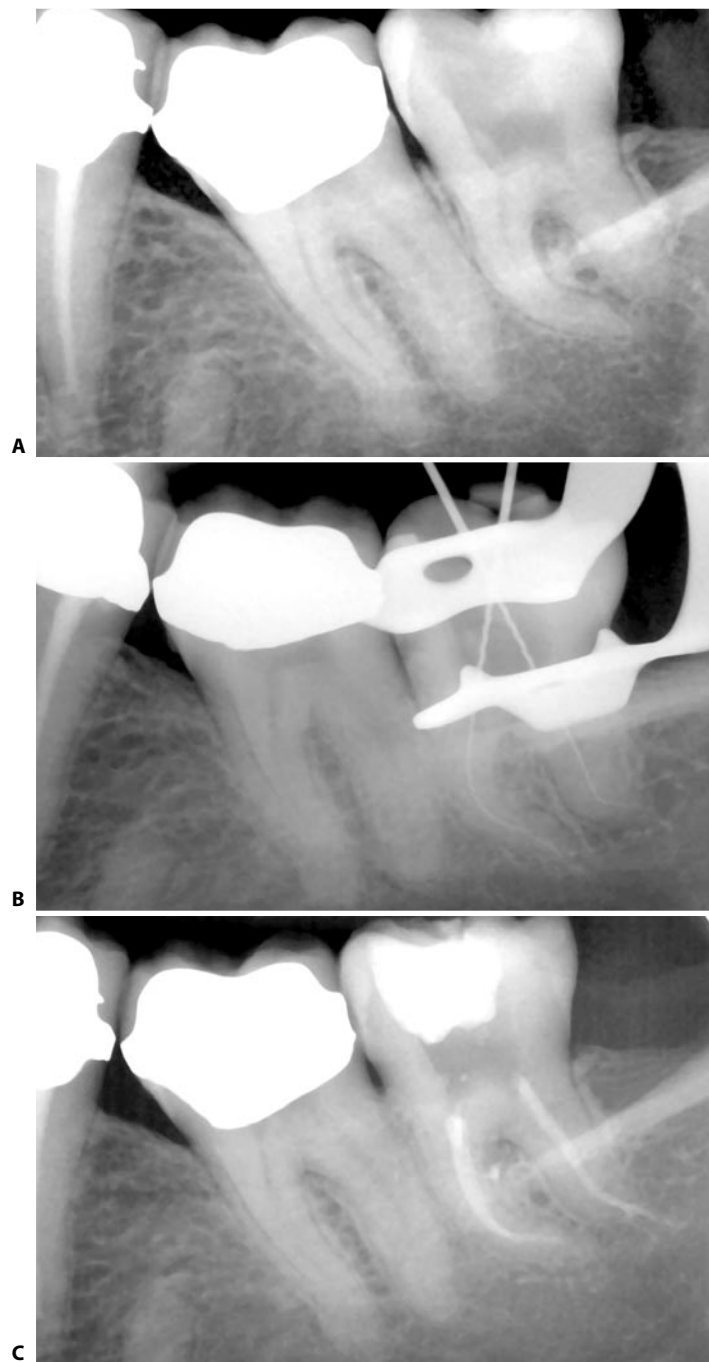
Endodontic treatment of a lower third molar. A. The preoperative radiograph shows the presence of rather short roots and accentuated curvature as well as very narrow canals. B. Intraoperative radiograph. C. Postoperative radiograph: note the obturation of a lateral canal situated at the level of the coronal third of the mesial root. The fine thickness of the distal walls of the mesial canals have been respected. The obturation using the Microseal Technique was carried out using a # 25 tip diameter condenser with .02 conicity.
